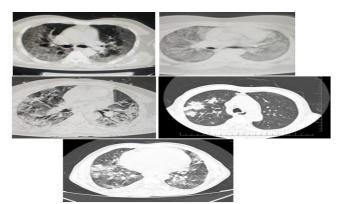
HRCT Chest in Symptomatic Primary Contacts of Covid-19
